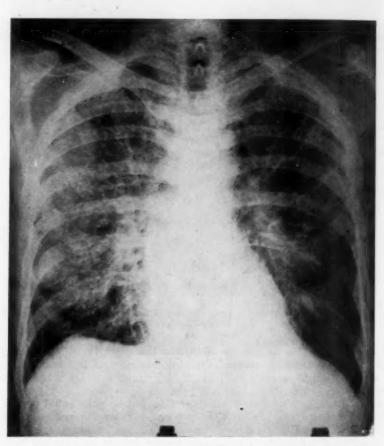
Case 3. Roentgenogram of chest March 4, 1948. In July 1947, a roentgenogram of the chest was negative. The x-ray picture remained unchanged from December 1947 through March 4, 1948.
